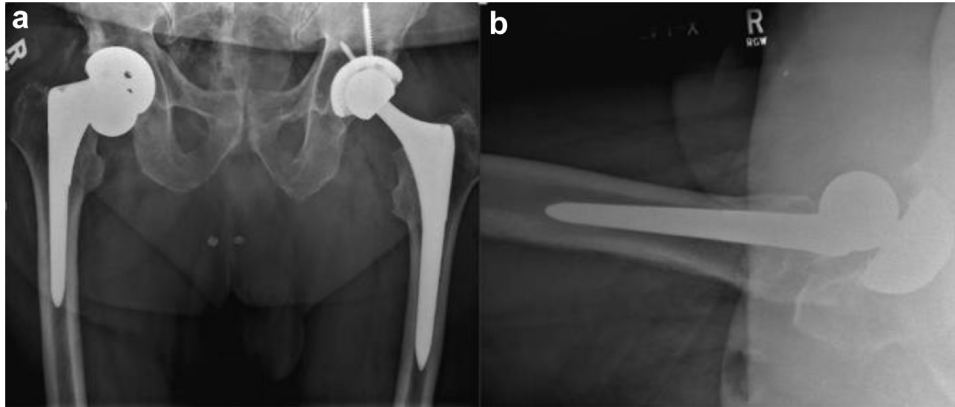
Anteroposterior pelvis (a) and lateral hip radiographs (b) from January 2018 demonstrating hardware failure consistent with dissociation at the right femoral head-stem interface. Left total hip arthroplasty was performed on 03/2017 by a different surgeon.
